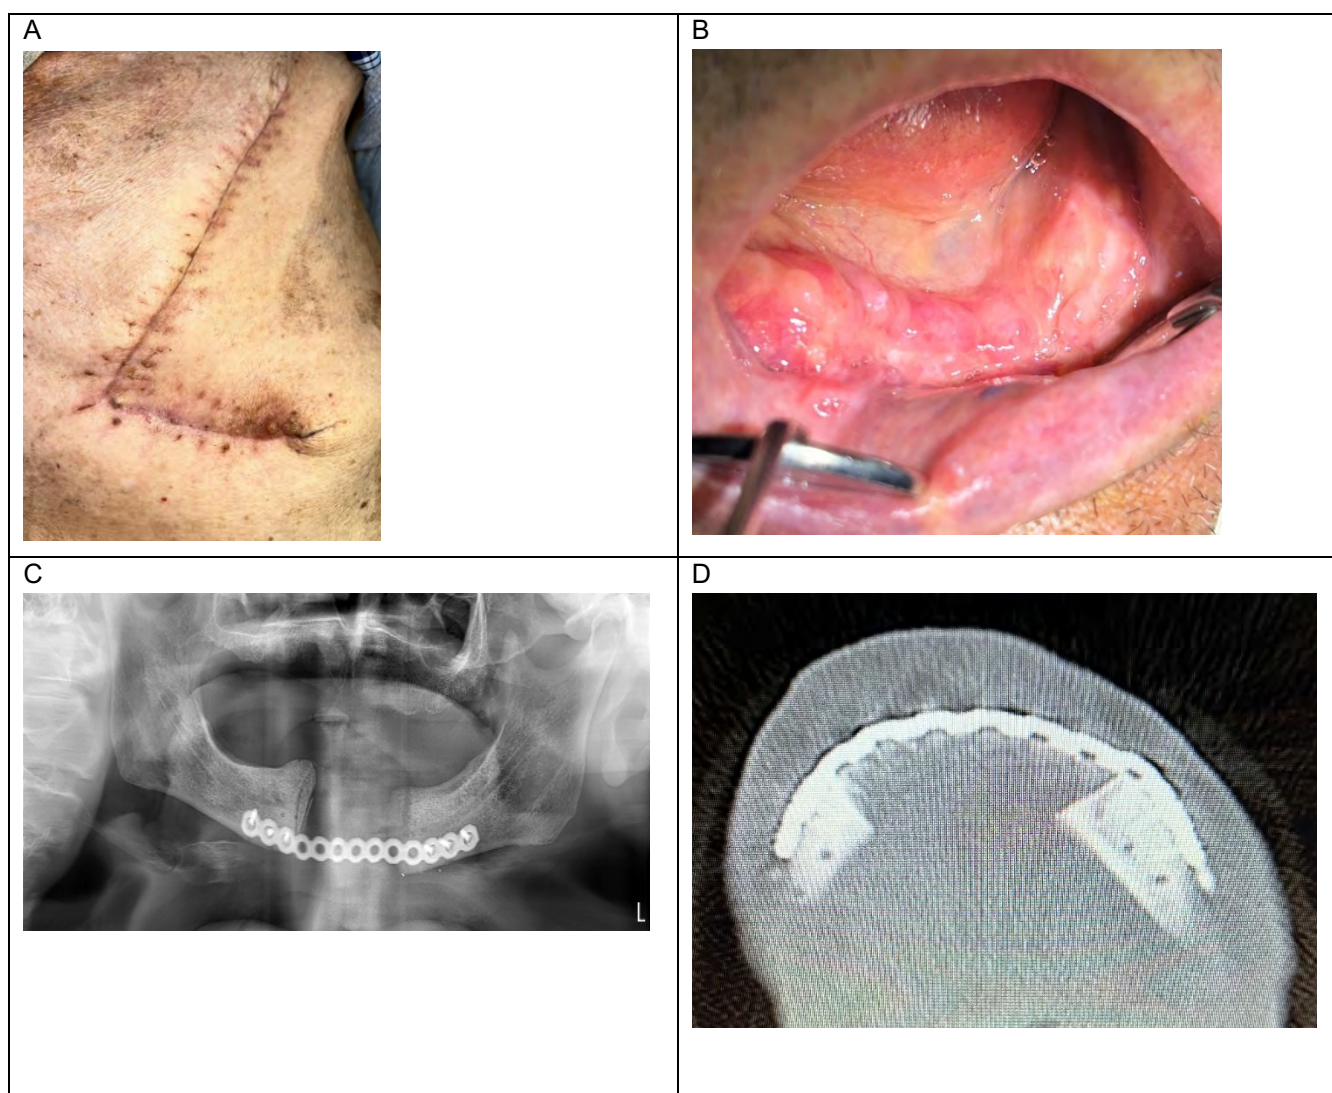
A: Clinical view of the donor site in the postoperative 2nd month. B: Intraoral view in the postoperative 2nd month. C: The image of postoperative OPG in the 2nd month. D: The image of postoperative CT in the 2nd month.
